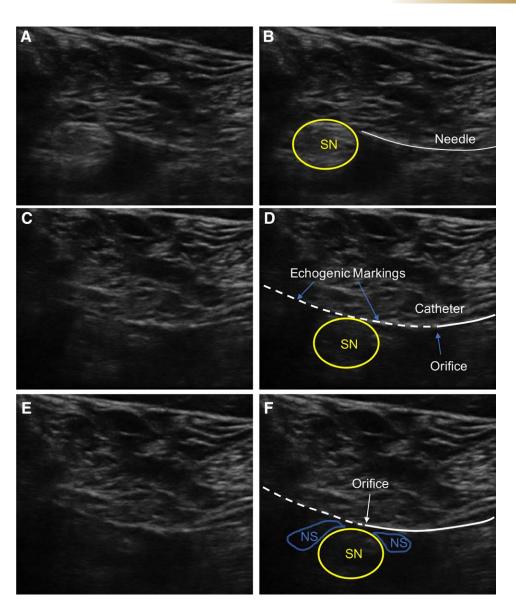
Ultrasound guided placement of a suture-catheter. A. The suture needle is advanced toward the SN. B, The needle and SN are labeled. C, The echogenic markings on the catheter are used to position the orifice adjacent to the nerve. The orifice is located where the echogenic markings terminate. D, The echogenic markings, catheter, orifice, and SN are labeled. E, Correct positioning of the orifice directly adjacent to the SN is confirmed by injection of NS through the catheter and visualization of spread around the nerve. F, The orifice, SN, and NS are labeled. NS indicates normal saline; SN, sciatic nerve.
